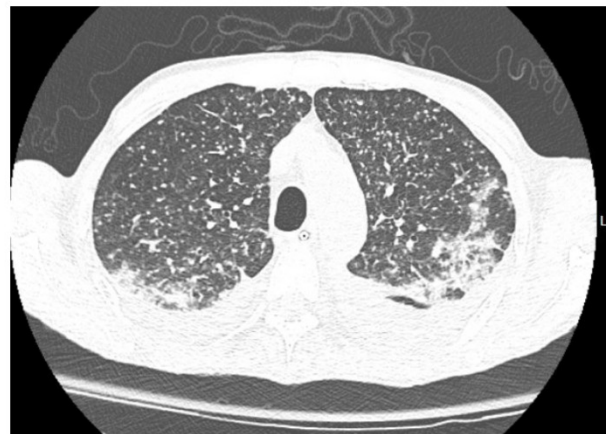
CTA of the chest suggesting miliary airspace disease
